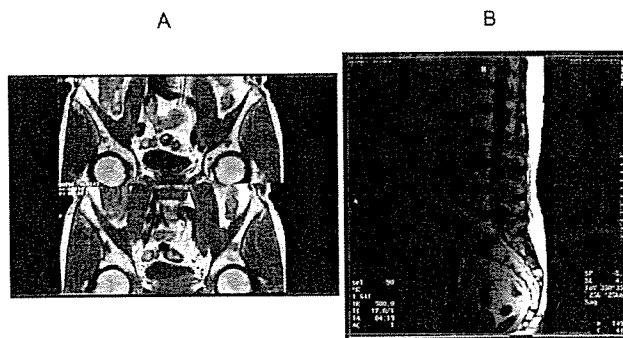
Magnetic resonance images of a patient with subclinical paroxysmal nocturnal hemoglobinuria. A, T1-weighted image of the pelvis. B, T1-weighted image of the thoracic and lumbar vertebrae.
